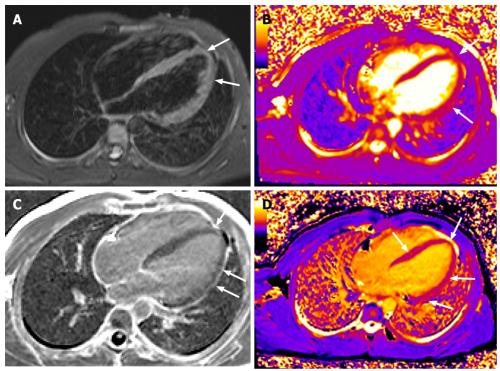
Cardiac magnetic resonance imaging. Horizontal long axis TIRM image (A) displaying high signal in the myocardium at the apex and along the free wall of the left ventricle (LV). Horizontal long axis T2 (B) and T1 (D) mapping depicting prolonged T2 and T1 relaxation times at the same area and in the middle septum (D). Horizontal long axis image post gadolinium administration (C) showing late enhancement at the apex and along the free wall of LV. There is also pericardial enhancement along the free wall of LV.
